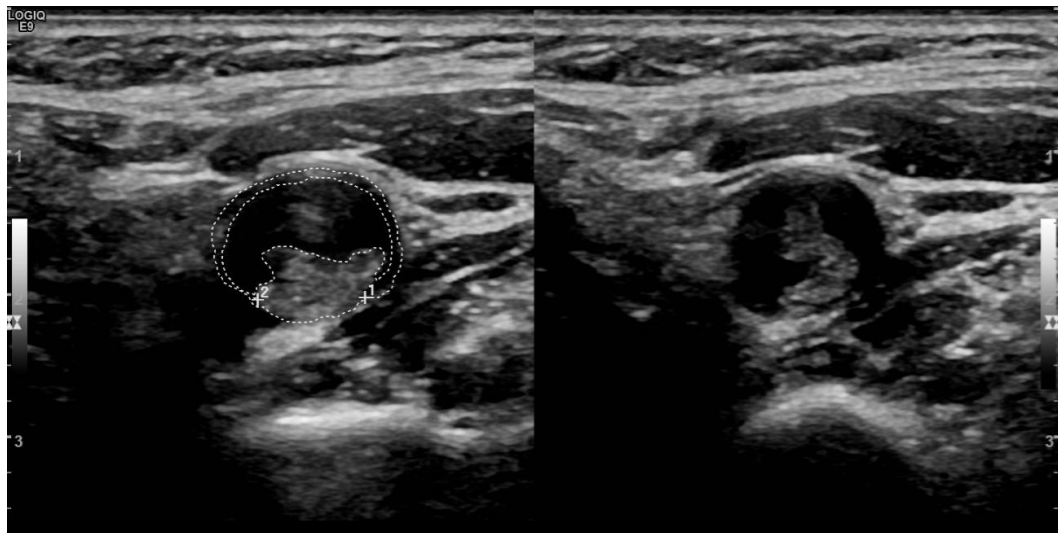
Left carotid artery ultrasound showing atheroma plaque producing 48% stenosis of the blood vessel.
